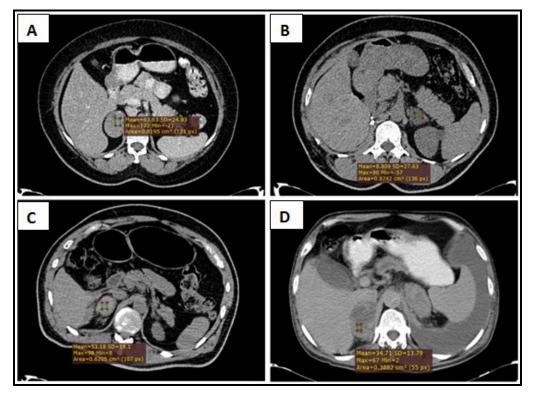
CT scans of adrenal incidentalomas (A) Lipid poor Adrenal adenoma: Enhancing mass lesion is seen on the right adrenal gland showing attenuation value of 63.6 HU (indicative of malignancy) in 70s contrast enhanced CT (B) Lipid rich Adrenal adenoma: Left adrenal mass with attenuation of 8.8 HU is seen on non-enhanced CT suggestive of lipid rich adrenal adenoma(C) Adrenal hematoma: Right adrenal gland is diffusely bulky with increased attenuation suggestive of adrenal hematoma on plain CT (D) Adrenal metastasis: A heterogeneously enhancing mass seen on the right adrenal gland showing attenuation value 34.7 on delayed scan consistent with metastasis.
